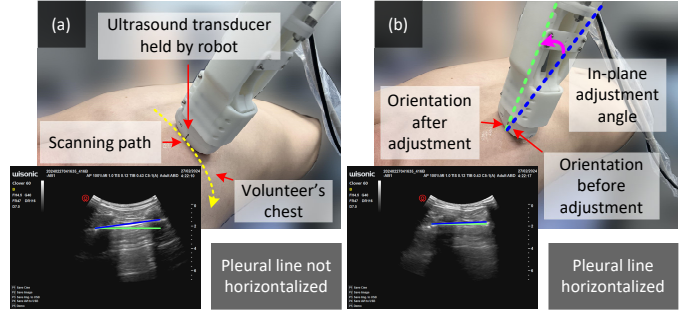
Snapshots taken (a) before and (b) after the autonomous in-plane orientation adjustment during teleoperated lung ultrasonography on a volunteer. The blue line in the ultrasound image marks the pleural line and the green line marks the horizontal reference.
